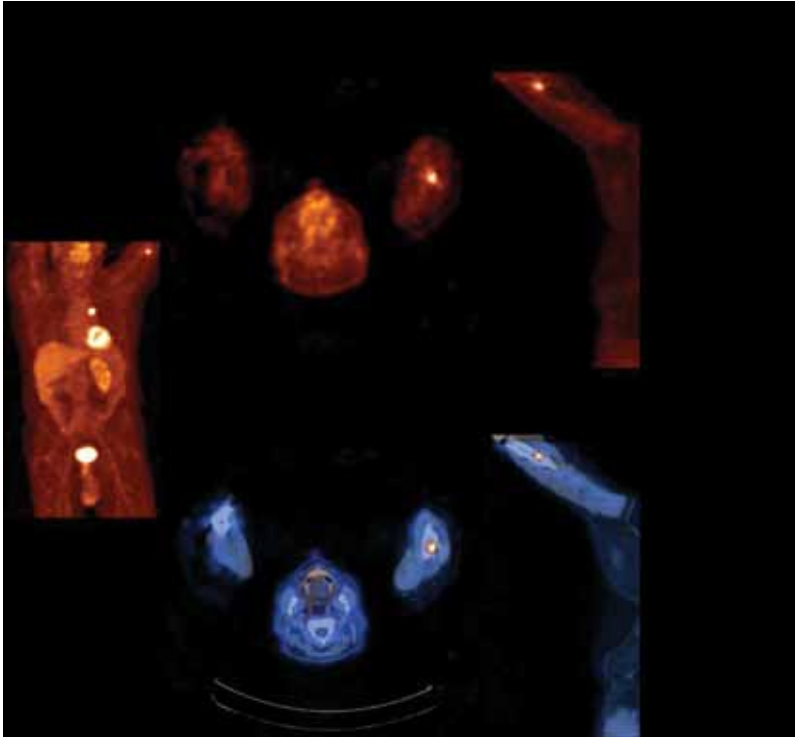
PET-CT scan of the same patient shows an increased FDG uptake in the small metastasis in the distal part of the left humerus.
